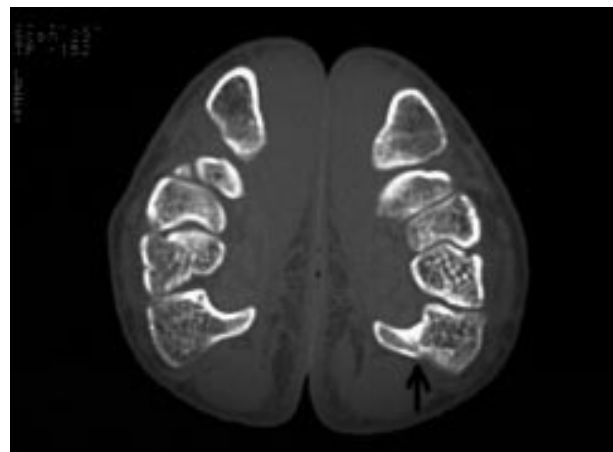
High density computed tomography scan of both wrists in the "praying position" showing a fracture through the base of the right hamate hook.
